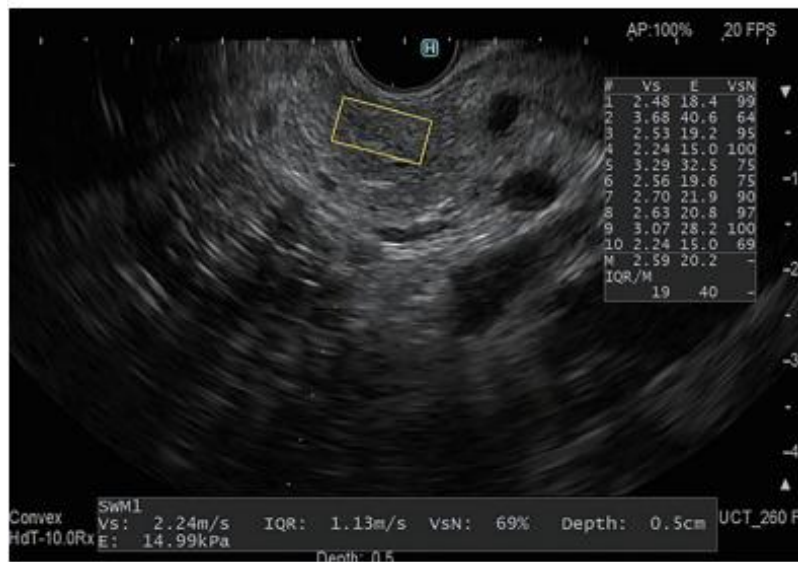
A),B) endoscopic ultrasound imaging; C) CT scan<sup>18</sup>
